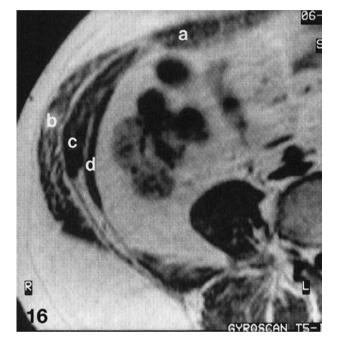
Transverse T2-weighted MR image depicting the muscles of the anterior abdominal wall; *a*, rectus abdominis muscle; *b*, external oblique muscle; *c*, internal oblique muscle; *d*, transversus muscle; *R*, lateral; *L*, medial
